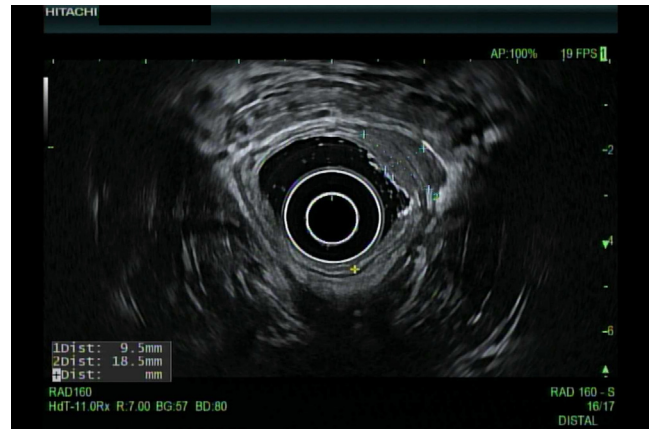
Submucosal lesion at the post-EMR site as seen on endosonographic imaging.
